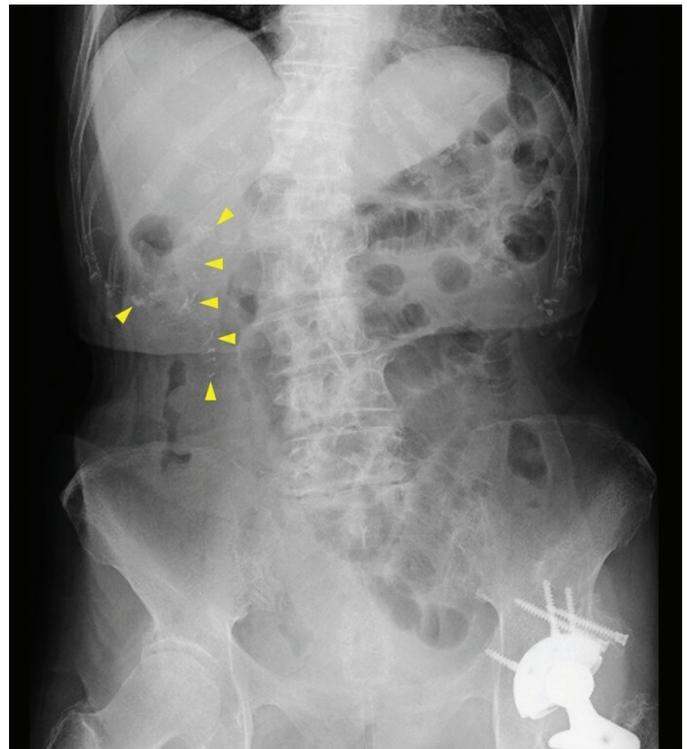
Abdominal radiography showing significant gaseous distention in the left quadrant and calcification in the right upper quadrant (arrowheads).
